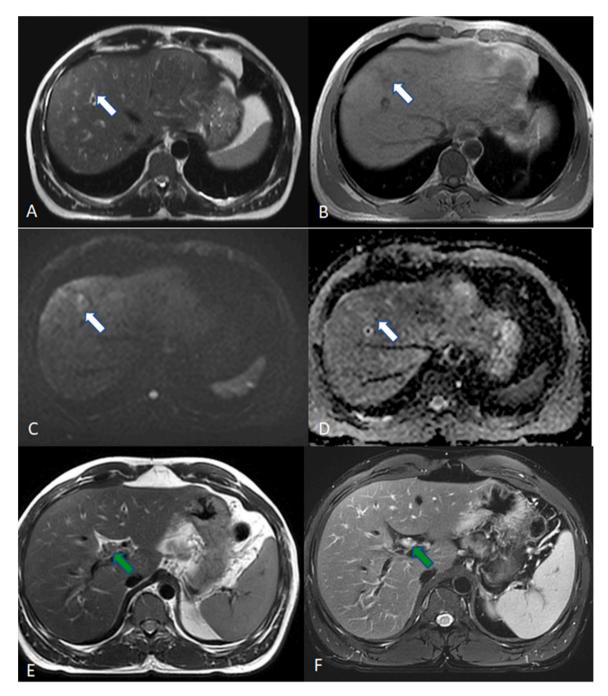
Abdominal MRI images: Axial T2WI (A & E), T1WI (B), DWI (C), Apparent Diffusion Coefficient (D), and fat suppressed T2WI (F) of a patient with Fasciola hepatica. The scans show peripheral subcapsular region ill-defined lesions in the right hepatic lobe which are slightly hyperintense on T2WI and hypointense on T1WI with facilitated diffusion (white thick arrows). Common hepatic duct has wall thickening and internal signal loss (green arrow).
